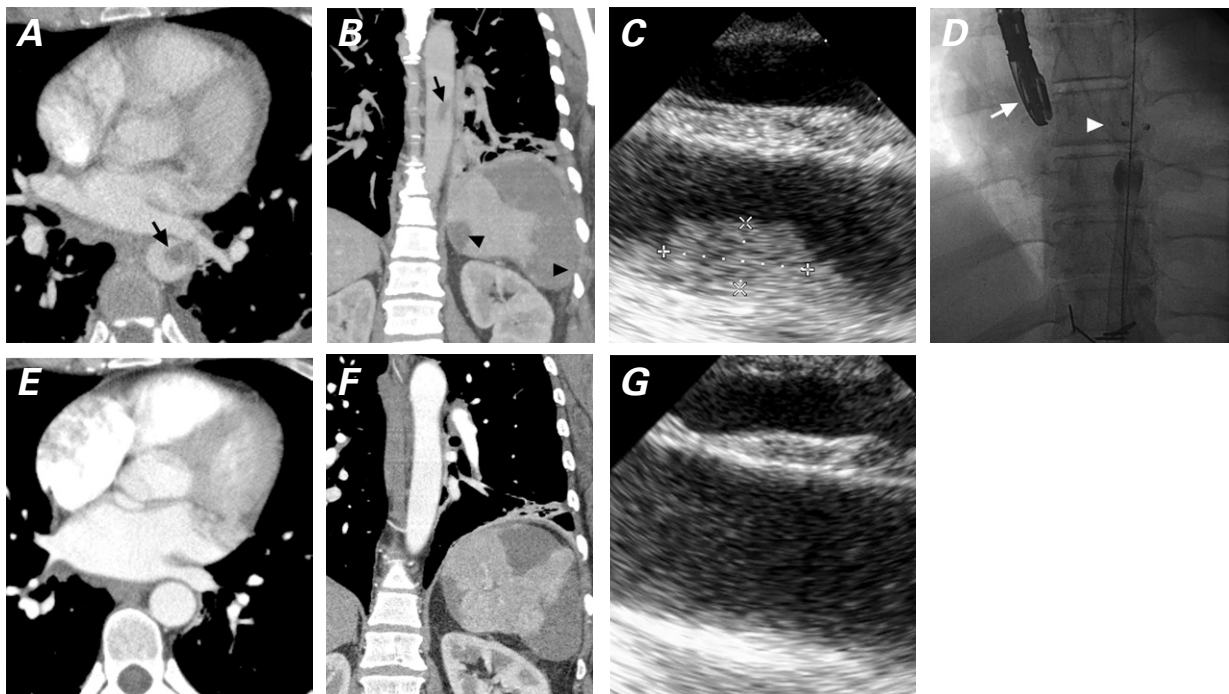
Preprocedural computed tomographic angiograms (CTAs) of the descending thoracic aorta show A) a noncalcified mass (arrow) (length, 22 mm; cross-sectional diameter, 11 × 15 mm), in the axial view, and B) the mass extending into the lumen of the thoracic aorta (arrow), as well as multiple splenic infarctions (arrowheads), in the sagittal view. C) Transesophageal echocardiogram (TEE) shows the mass. D) Fluoroscopic view shows the TEE probe (arrow) and AngioVac catheter (arrowhead) in the descending thoracic aorta. Eleven months later, CTAs show no residual mass in the E) axial and F) sagittal views. G) Postprocedural TEE shows no residual mass.
